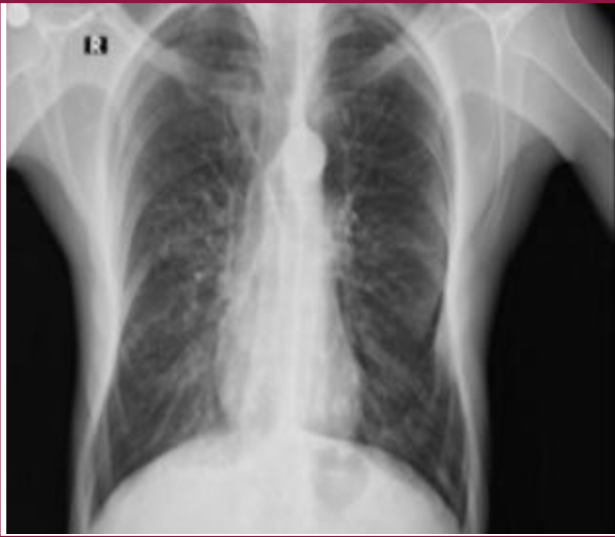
Posteroanterior chest radiograph demonstrating increased aeration of the upper lung zones, bilateral flattening of the hemidiaphragms, widening of the intercostal spaces, and a vertically oriented narrow cardiac silhouette ("droplet heart" appearance).
